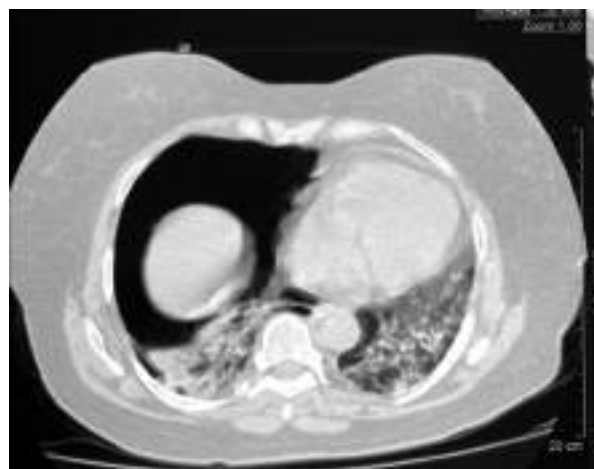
Right pneumothorax on chest CT after one month of hospitalization
